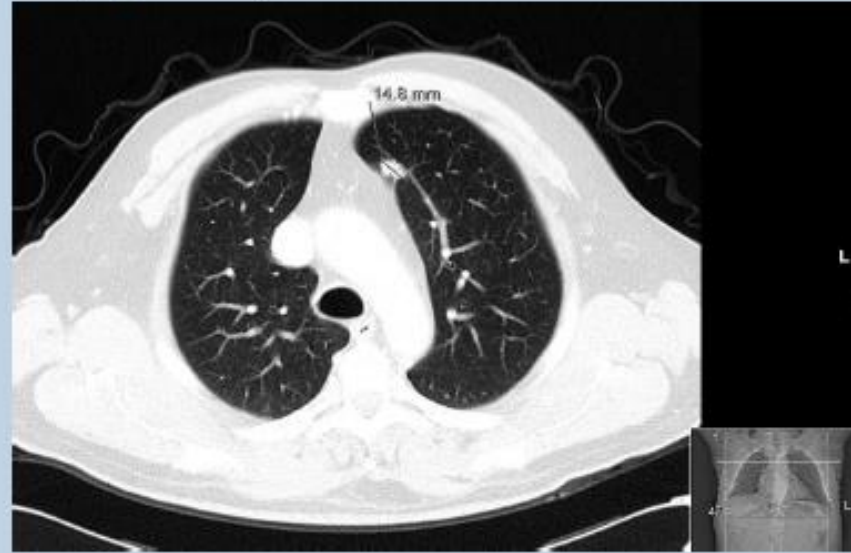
Thoracic CT showing the lung metastasis in the apical segment
